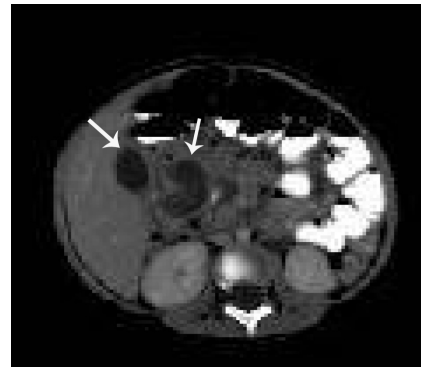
Contrast-enhanced abdominal CT scan showing 5 x 2.5 cm (arrows). Right subhepatic abscess and other abscesses between intestinal loops and behind the urinary bladder.
